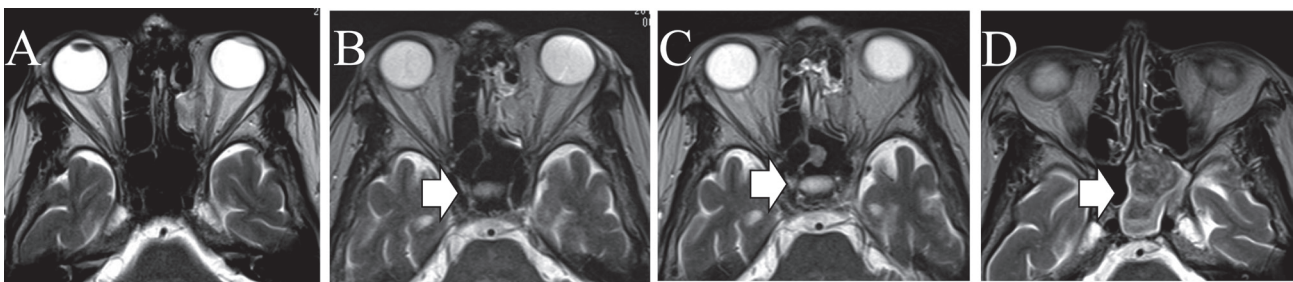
(A–D) Axial MRI showed the change of the size of the tumor in left sphenoid sinus at (A) 12, (B) 13, (C) 14, and (D) 15 years after radical nephrectomy. The tumor was not detected at 12 years after the radical nephrectomy (A), but was first detected at 13 years (arrow) (B), and its size increased gradually over 2 years (arrow) (C, D). (D) Axial MRI showed that the tumor had low signal intensity in (arrow) (D) the T2-weighted image.
